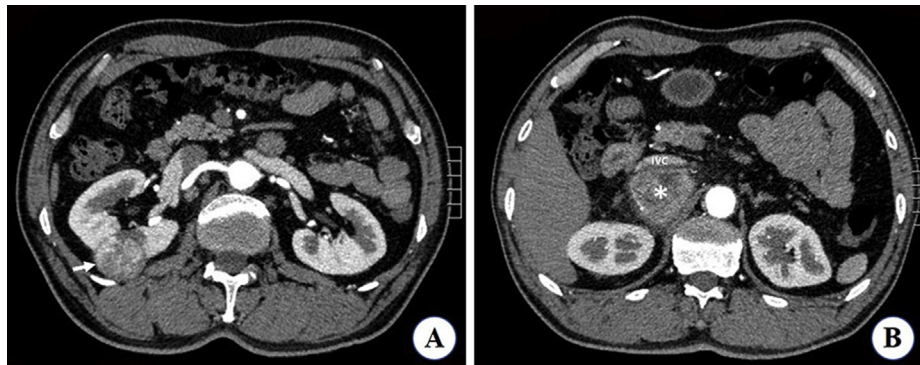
CT scan (1A) demonstrate a 4.8cm diameter heterogeneously right renal mass (arrow) and (1B) show a single well-circumscribed homogeneously enhanced mass close to the right renal pedicle. IVC: inferior vena cava.
